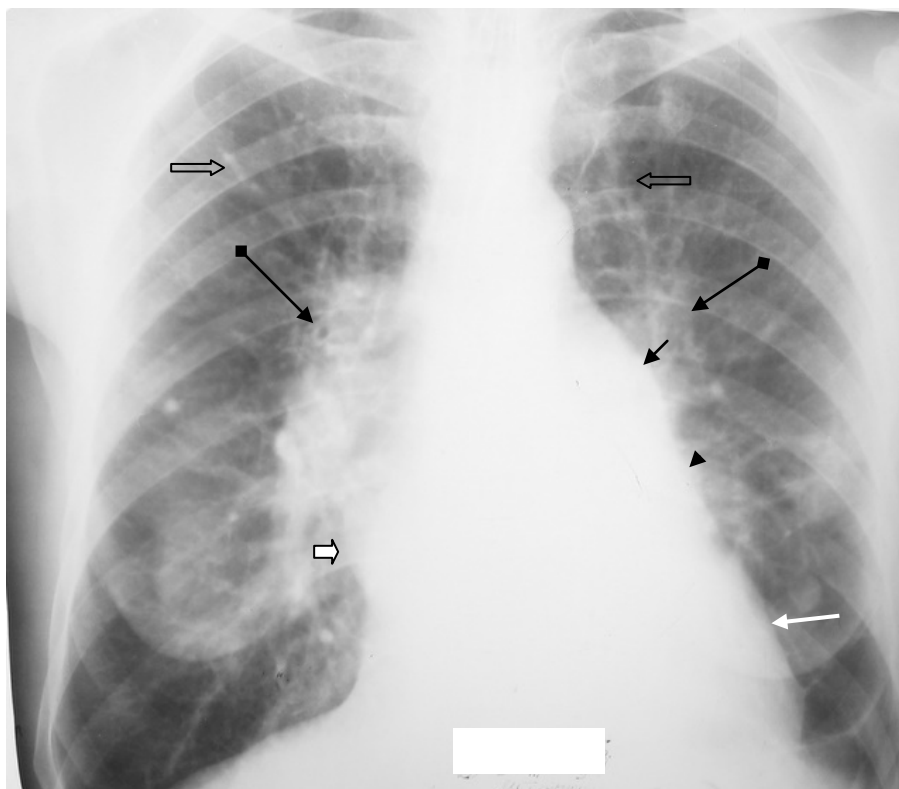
The frontal chest radiograph. Shades of hila of lungs are increased at the expense of expansion of vascular trunks forming them (an arrow with a rhombus). Enlargement of the upper zone vessels from both sides (thick arrows). The heart shadow is expanded (mitral configuration). Increase in arches on the left contour: pulmonary artery (black arrow), the left atrium (small black arrow), left ventricle (white arrow). The increased left atrium forms an additional arch on the right contour of heart (figured arrow). Mitral insufficiency. Signs of venous stagnation in lesser circulation
